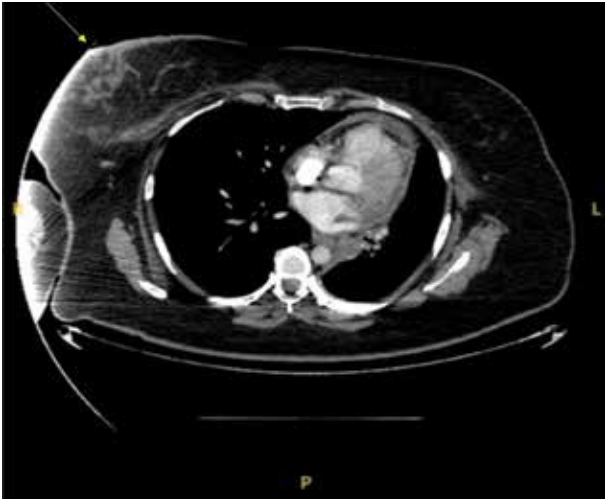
Asymmetrically increased density (yellow arrow) and edematous appearance of both breast tissue and the skin on thorax CT
